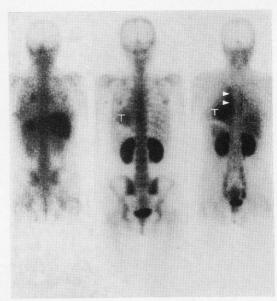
67Ga scintigraphy (left) showed no accumulation to the tumor. 99mTc-MDP (middle) and 99mTc(V)-DMSA (right) accumulation to the tumor was recognized (P-A view, T: tumor). In 99mTc-MDP image, increased renal uptake was recognized, but considered idiopathic. In 99mTc(V)-DMSA image, descending aorta was visible as blood pool (▲).
